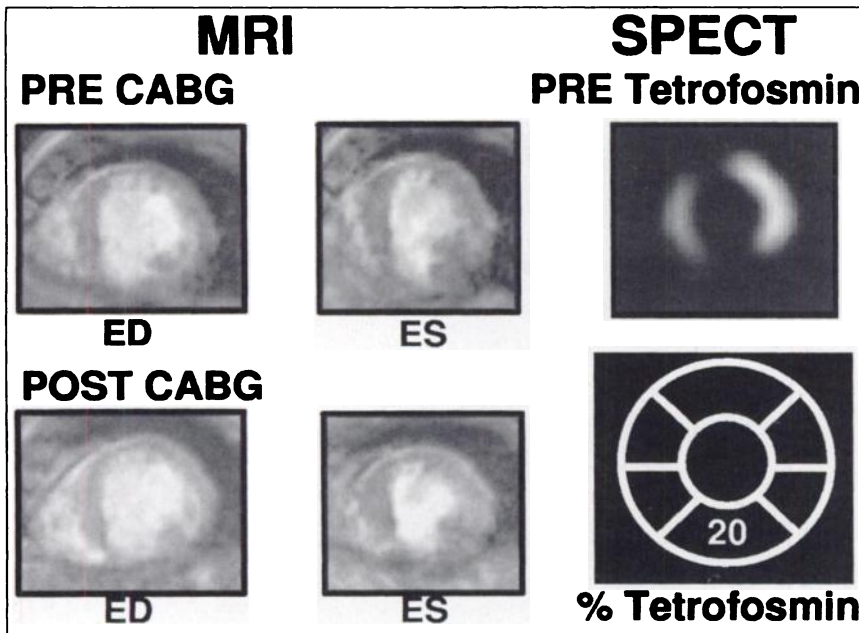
Corresponding MR and ^{99m}Tc -tetrofosmin SPECT short-axis images of patient with inferior and anterior infarction (top row). Corresponding MR images 3 mo after coronary artery bypass grafting (CABG) (bottom row). Both inferior and anterior perfusion abnormalities at rest before surgery (20% of maximum uptake in inferior segment; see bull's-eye analysis, left bottom row) correspond to obvious myocardial wall thinning on short-axis MR images. There was no improvement in regional or global function 3.5 mo after CABG (EF 19% before and 22% after surgery). ED = end diastolic; ES = end systolic.
